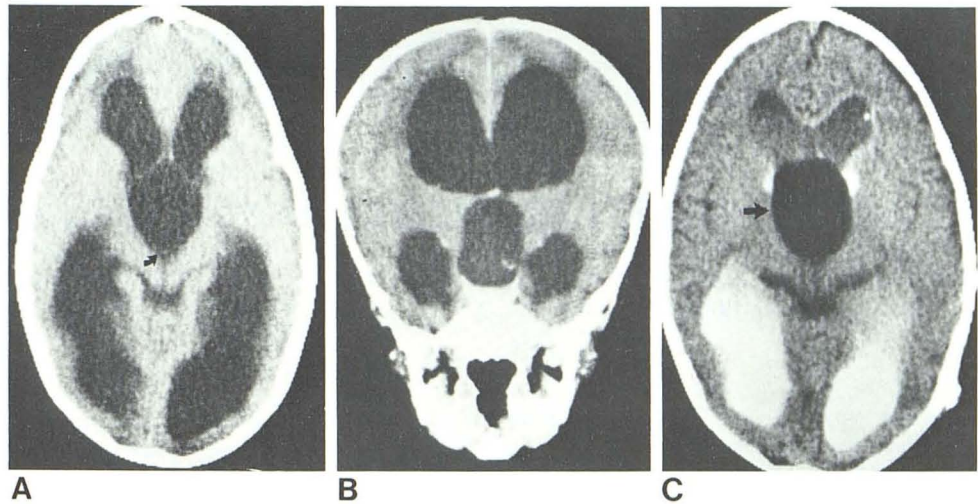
A, Axial CT scan shows hydrocephalus, rounding of posterior aspect of cyst, and flattening of colliculi (arrow). B, Coronal scan with large cyst displacing foramen of Monro upward (arrow) producing obstructive hydrocephalus. Third ventricle was not discernible. C, Metrizamide ventriculogram shows round mass effect (arrow) on floor of posterior third ventricle. Metrizamide did not enter cyst.
